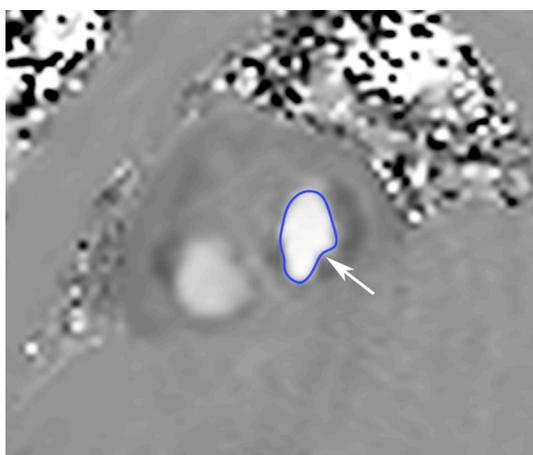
Measurement of transmitral flow. Phase-encoded MRI image obtained with a phase-contrast sequence show a region of interest placed at the mitral orifice (arrow). The transmitral flow curve was obtained from this region of interest.
